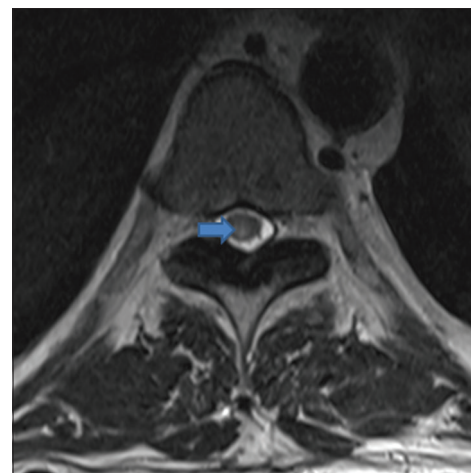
T2-weighted axial section at T10-T11 level showing intramedullary hyperintense signal changes (arrow) suggesting cord edema
